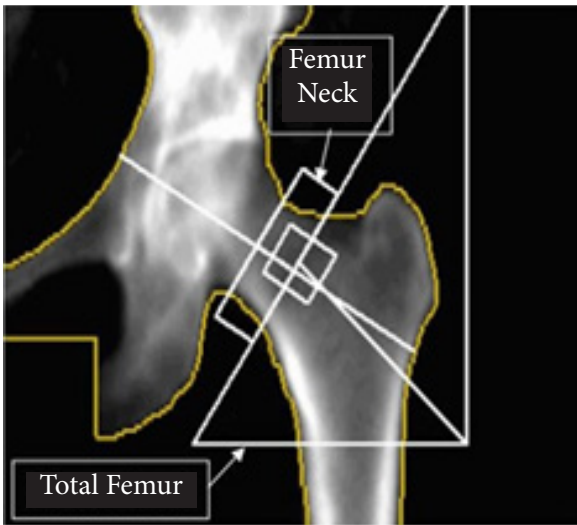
Analysis of bone mass in the left femur. Dual-energy X-ray absorptiometry image of the left hip. Source: Lorente Ramos et al., 2012.
